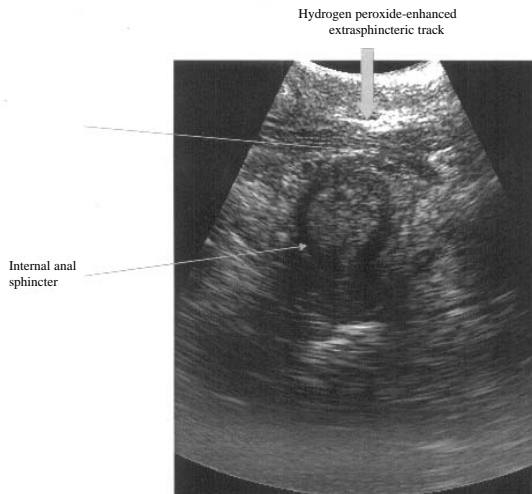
Hydrogen peroxide-enhanced transperineal ultrasound of the same patient showing the fistula transgressing the external anal sphincter (arrowhead).
